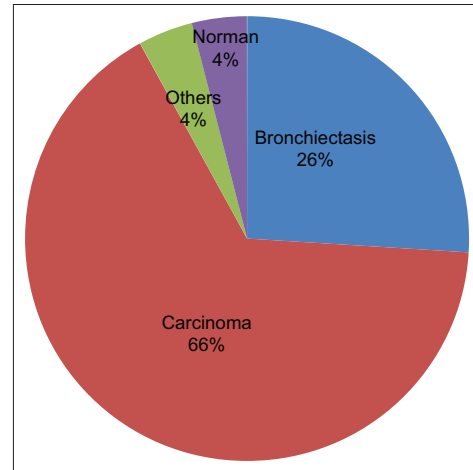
Contrast-enhanced computed tomographic findings
